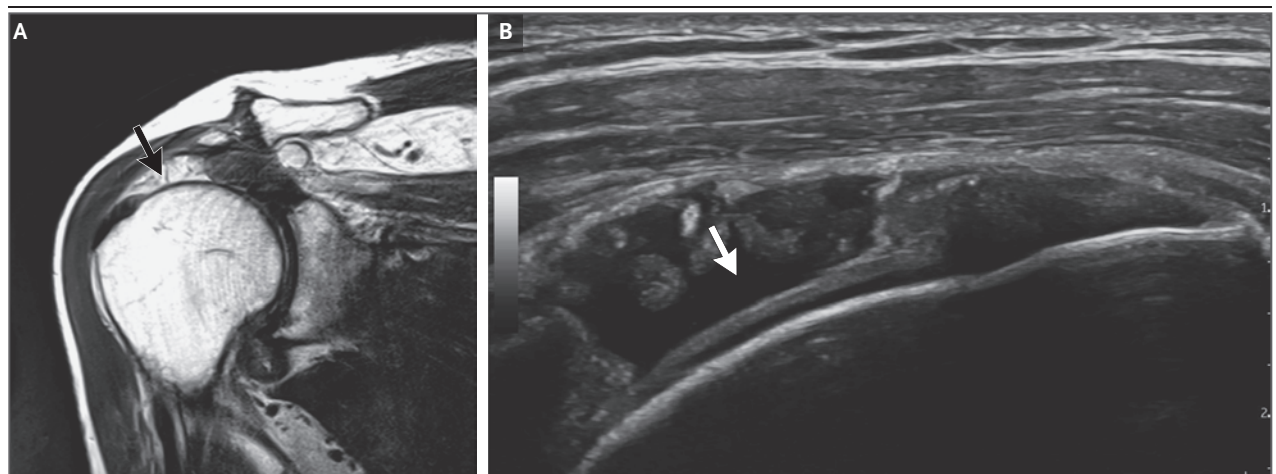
Magnetic Resonance Imaging and Ultrasonography of a Rotator-Cuff Tear.
